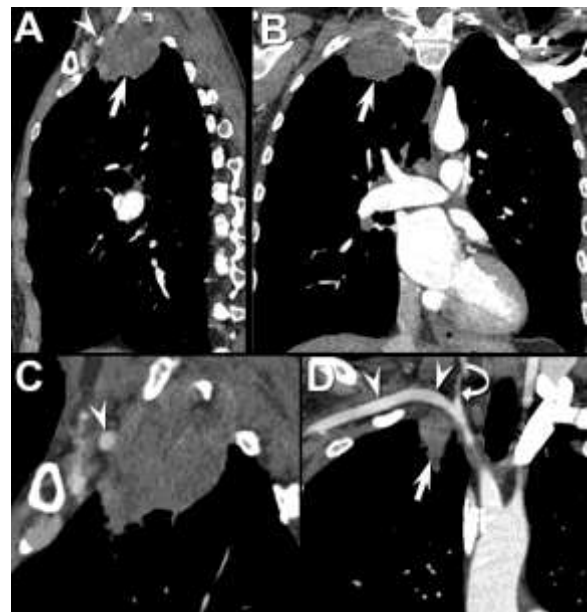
Sagittal (A and C) and coronal (B and D) enhanced chest CT images.
